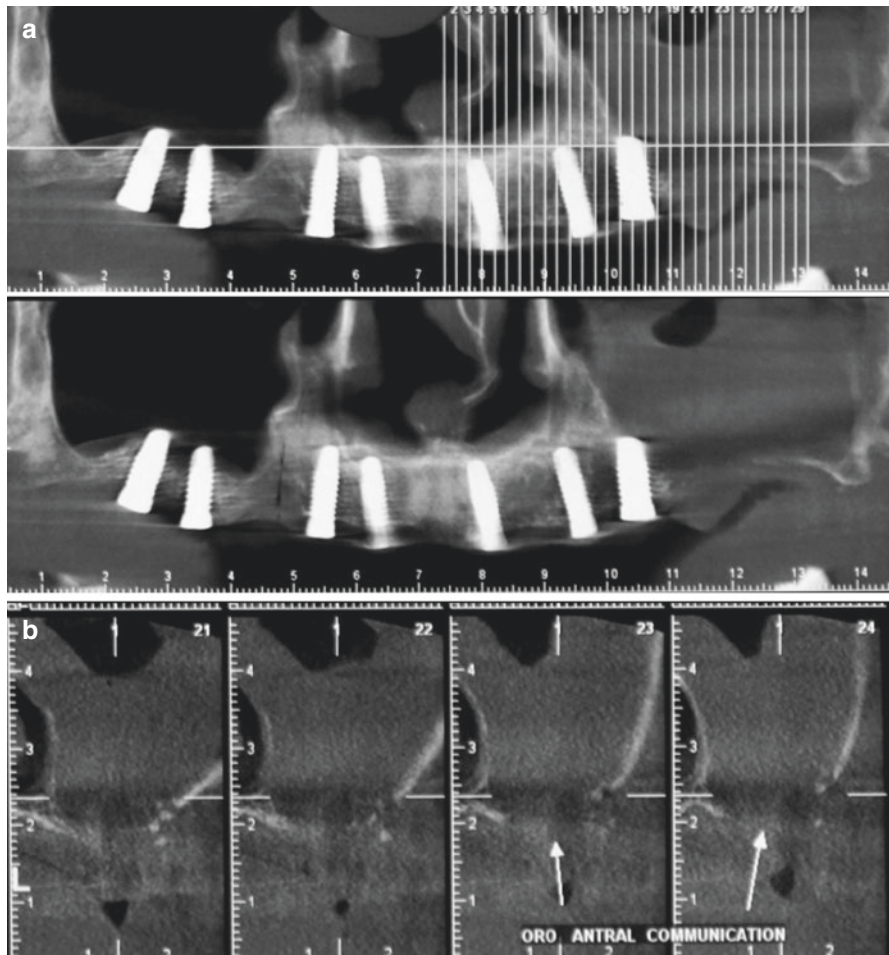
Case of Oro-antral fistula following the removal of a failed implant placed at the left upper first molar site due to a postoperative infection and sinusitis. Note the opacity of the left antrum in the CBCT (a, b) and the granulation tissue at the site of implant removal (c). The granulation tissue invaginating from the sinus membrane and mucosa was removed and the site was debrided and defistulized. Affected and thinned bone from around the fistula was also removed (d, e). The buccal fat was approached and pulled toward the defect with a fine hemostat while taking care to preserve the fat pad’s capsule (f, g). Two holes are drilled transpalatally in the medial sinus wall and the buccal fat is pulled inside the sinus cavity via a suture and tied to the medial sinus wall, forming a barrier between the sinus and the oral cavity (h–j). The buccal fat pedicle is split in half and the outer half will be used to provide coverage for the oral mucosa where the bony defect exists. Graft material is placed inside the sinus cavity and between the pedicled buccal fat lobules (k). The outer buccal fat lobule is sutured to the palatal mucosa, completely isolating the graft material and the sinus cavity from the oral mucosa. Final closure is obtained by suturing the mucoperiosteal flap (l). Postoperative follow-up after 10 days (m)
